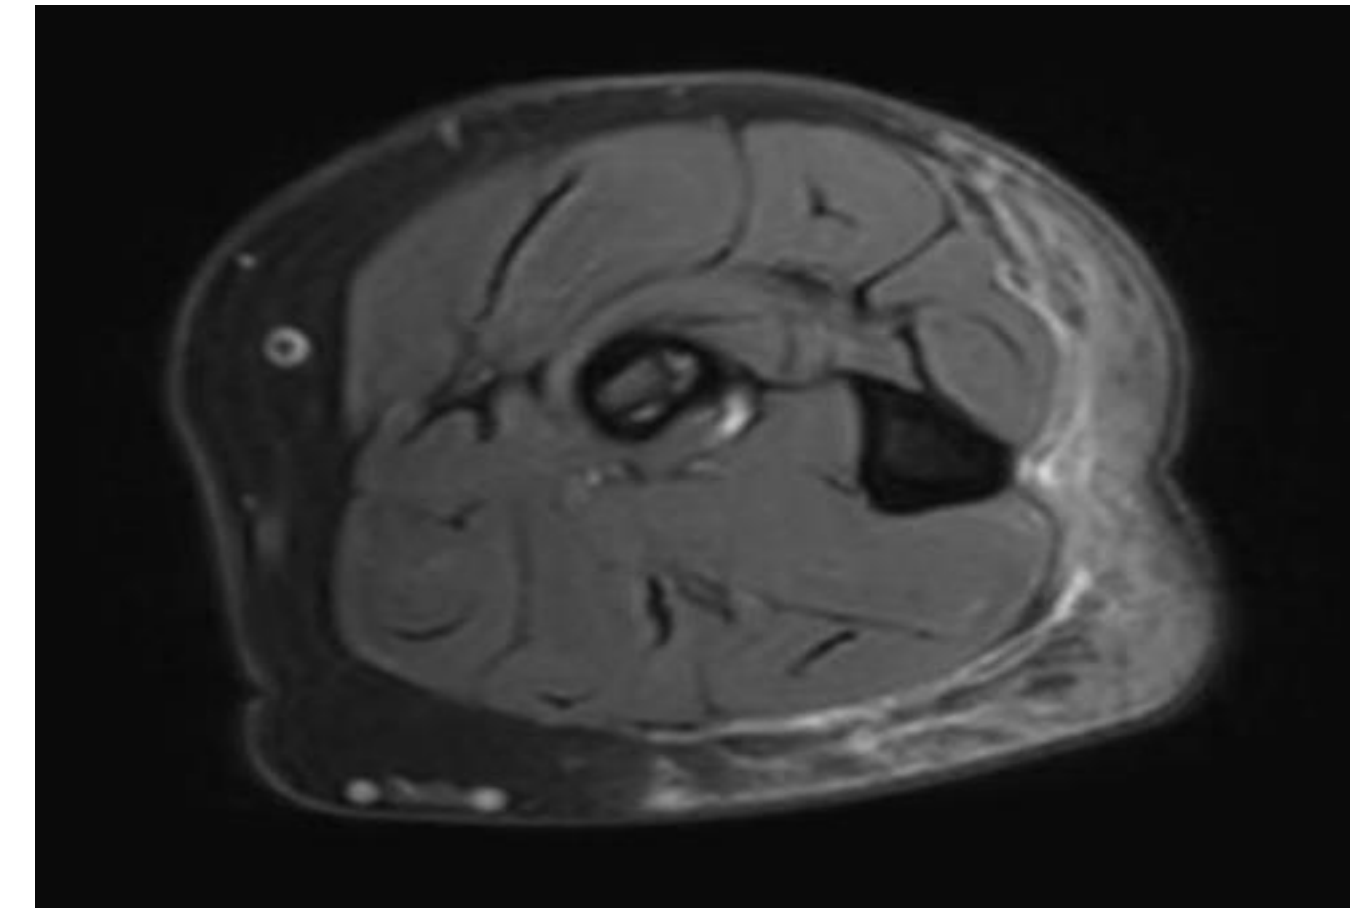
T2 enhanced MRI of the forearm revealing subcutaneous edema and inflammation.
